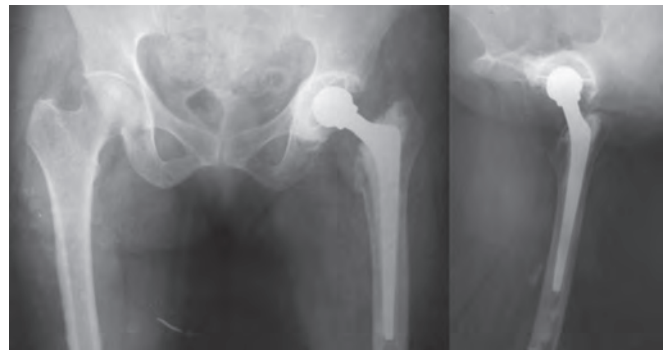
X-ray at 6th month follow-up
